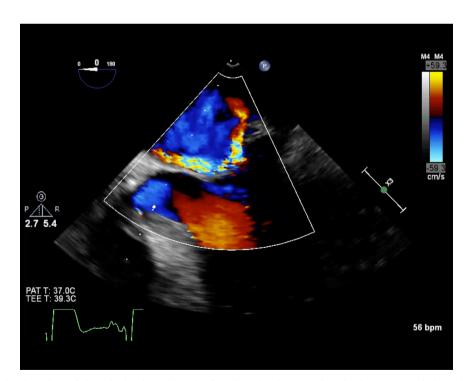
Midesophageal 4-chamber view of the mitral valve with color-flow Doppler demonstrating simultaneous anteriorly and posteriorly directed mitral regurgitation jets.
